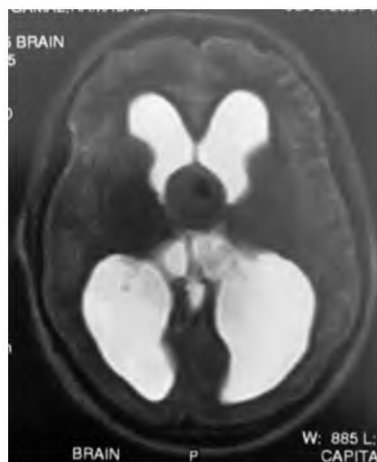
MRI brain of a 33 year old male patient with headache, vomiting and blurring of vision for 2 months, the T2 sequence showed a well circumscribed third ventricular lesion.
